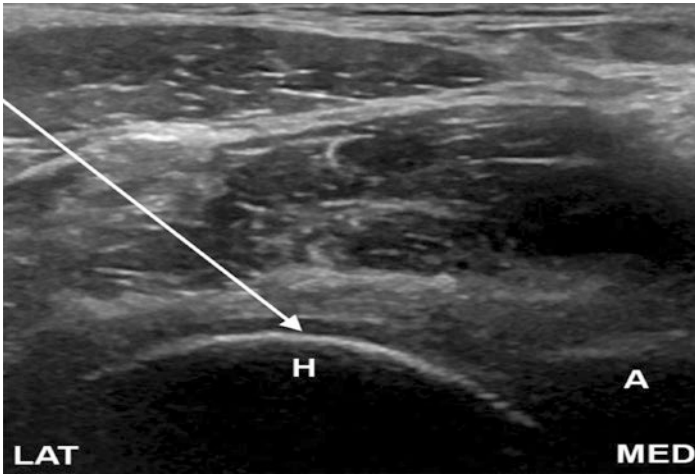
Ultrasound view of the hip. (Courtesy of Wikimedia Commons)
